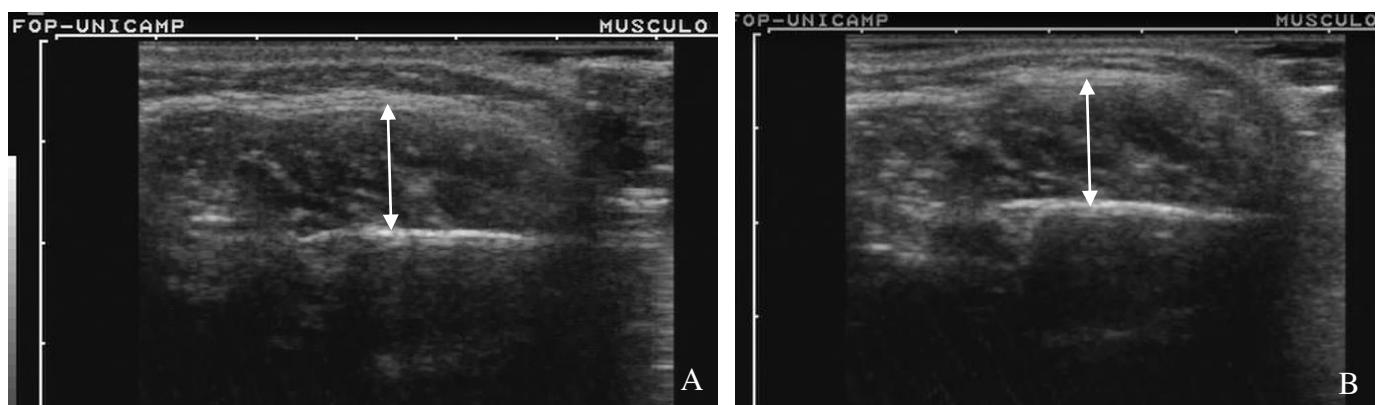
Ultrassonografia do músculo masseter em repouso (A) e durante apertamento dentário (B). As flechas indicam a espessura muscular mensurada.
